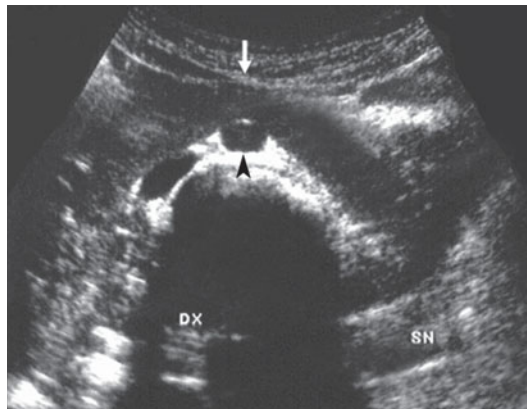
Horseshoe kidney. The axial sonogram shows the anterior fusion of the lower renal poles (*arrow*) in front of the aorta (*arrowhead*), with the structure of the isthmus similar to normal renal parenchyma
